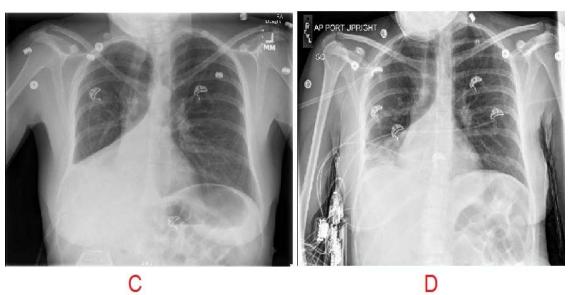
Chest X-rays Findings
